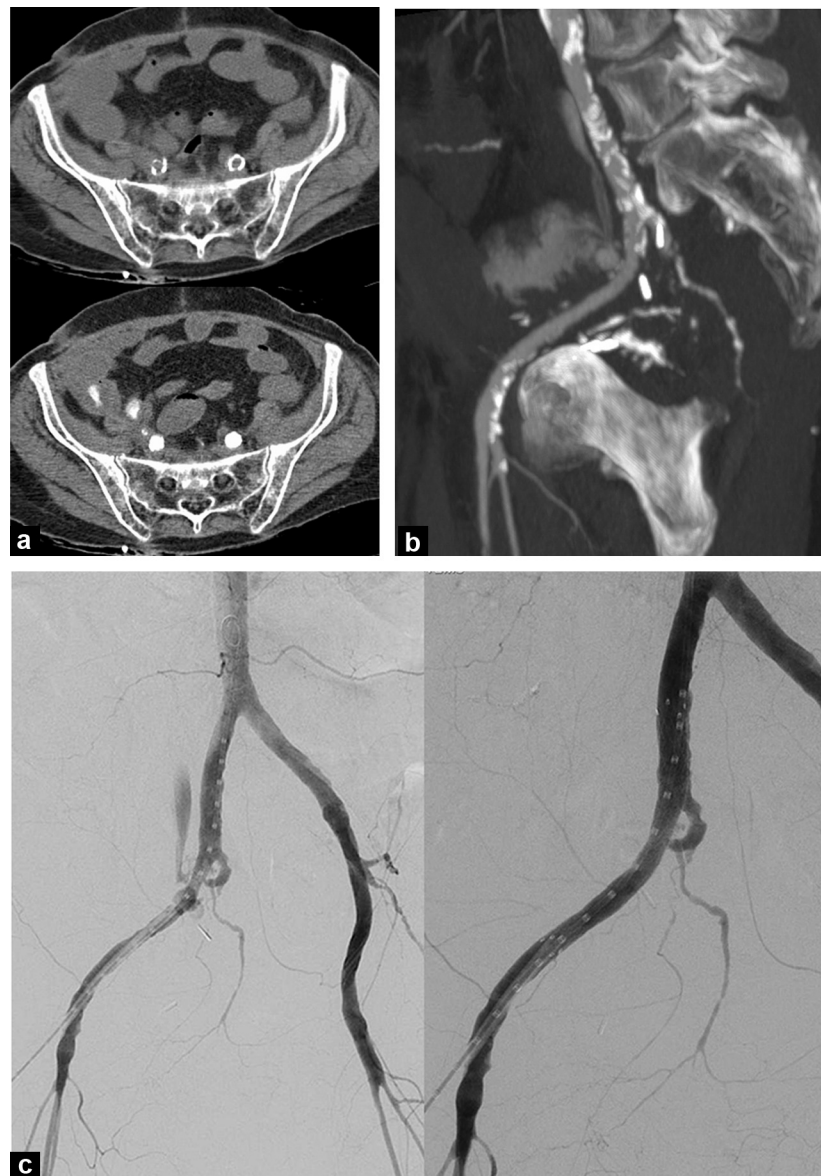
a: abdominal and pelvic CT (upper image) then with contrast enhancement in the arterial phase (lower image); b: abdominal and pelvic CT with contrast enhancement in the arterial phase. Oblique sagittal MIP reconstruction; c: iliac arteriography, pre-treatment (left image) and post-treatment appearances (right image).
